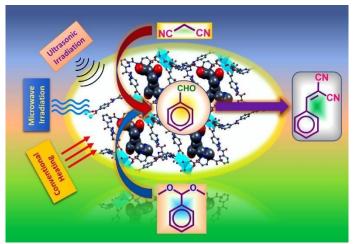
One-pot tandem deacetalization-Knoevenagel reactions catalyzed MOF using conventional heating, microwave and ultrasonic methods.
